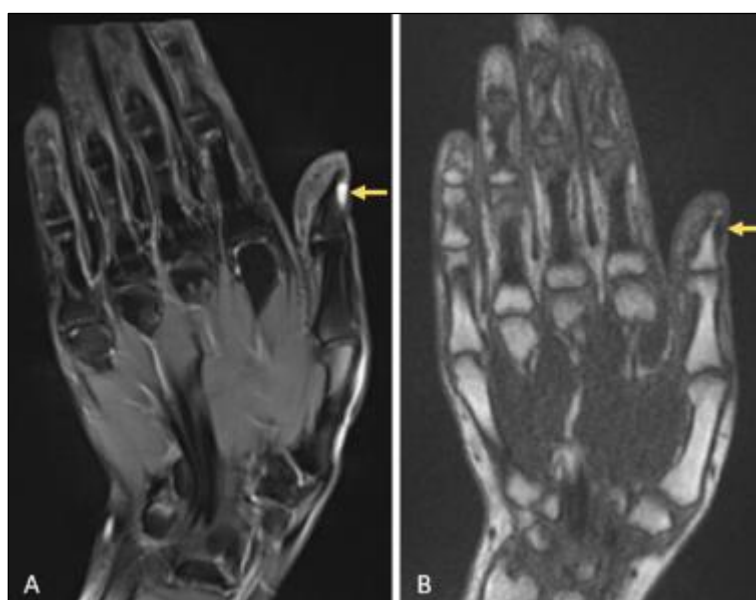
Coronal MRI of the hand. (A) Fat-suppressed PD/T2-weighted image: the subungual lesion of the thumb shows marked signal hyperintensity (arrow). (B) T1-weighted image: the same lesion shows low to intermediate signal intensity (arrow). MRI, magnetic resonance imaging; PD, proton density
